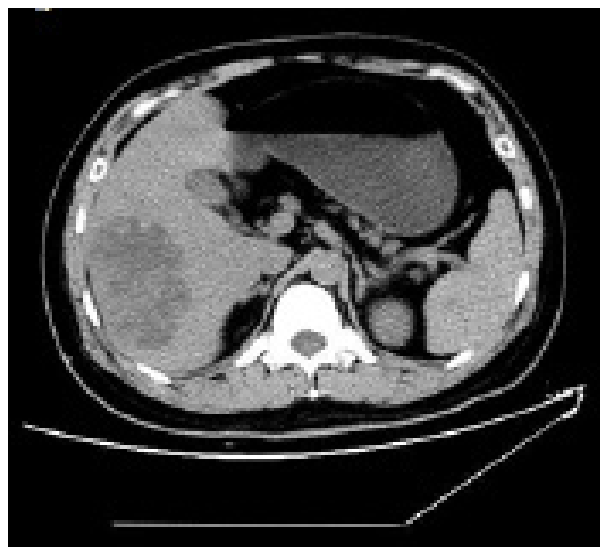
Enhanced-computed tomography of abdomen
